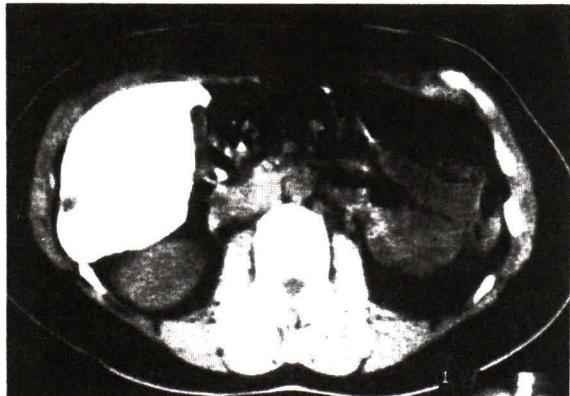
Lipiodol CT scan of hepatocellular carcinoma taken only one week after TOCE shows the entire liver opacified with lipiodol, which makes it impossible to identify the exact location of the tumor.
